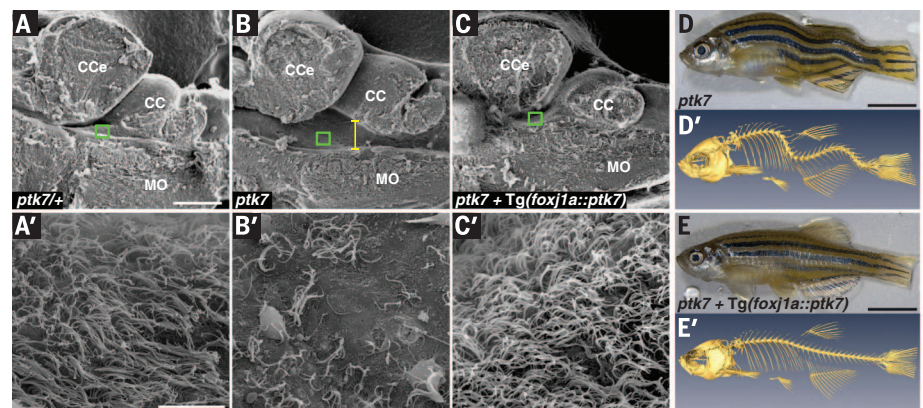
ptk7* mutant fish exhibit hydrocephalus, EC cilia defects, and spinal curves, all of which are prevented by transgenic reintroduction of *ptk7* specifically in motile ciliated cell lineages. (A to C) Representative sagittal SEM images of the brains of a *ptk7*^{+/+} control [*n* = 6 (A)], a *ptk7* mutant [*n* = 6 (B)], and a *ptk7* mutant expressing Tg(*foxfj1a::ptk7*) [*n* = 6 (C)], all at 2.5 months of age. The yellow line in (B) demarcates hydrocephalus. Green squares indicate the areas shown in corresponding high-magnification SEM images (A' to C'). (D to E') Representative fixed [(D) and (E)] and μ CT-rendered [(D') and (E')] lateral views of an adult *ptk7* mutant [(D) and (D')] and an adult *ptk7* mutant expressing Tg(*foxfj1a::ptk7*) [(E) and (E')]. CCE, corpus cerebelli; CC, crista cerebellaris; MO, medulla oblongata. Scale bars, 250 μ m [(A), (B), and (C)], 10 μ m [(A'), (B'), and (C')], and 5 mm [(D) and (E)].
